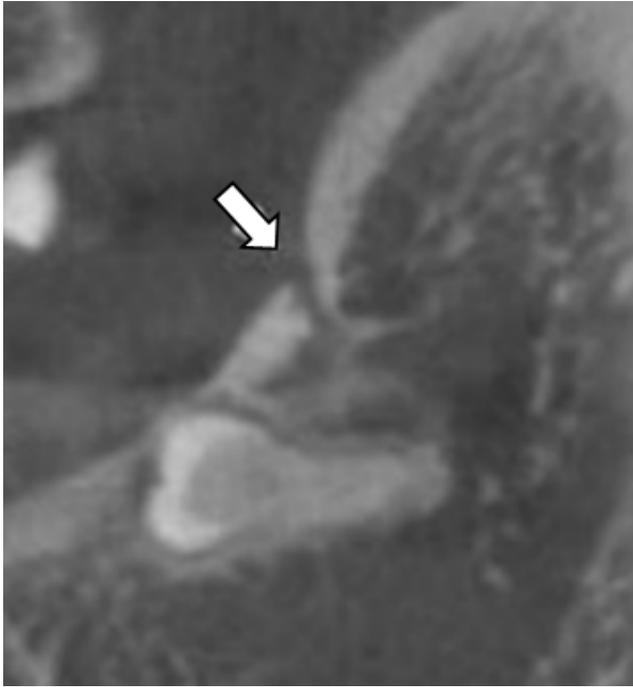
Sagittal section of CBCT showing retromolar canal type A
